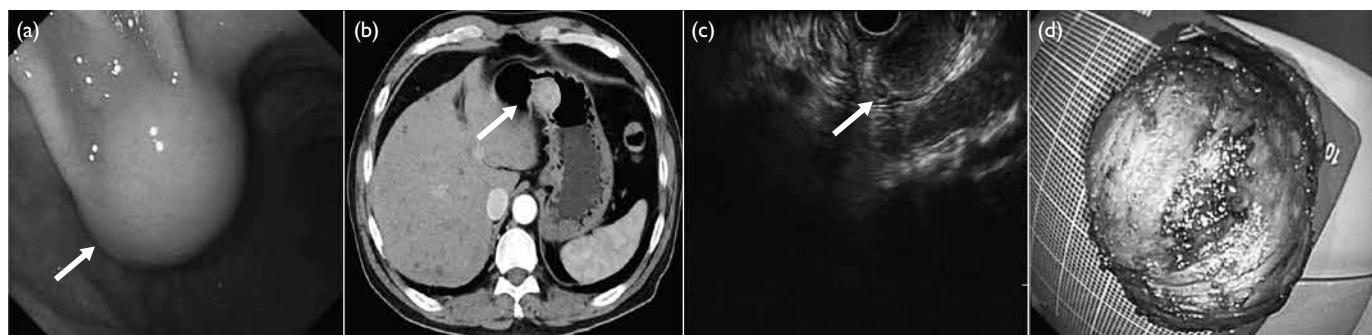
(a) The submucosal tumour is located at the gastric angle (arrow). (b) Abdominal computed tomography shows a mass in the gastric angle (arrow). (c) Endoscopic ultrasound reveals a hypoechoic lesion (arrow). (d) The submucosal lesion was completely resected
